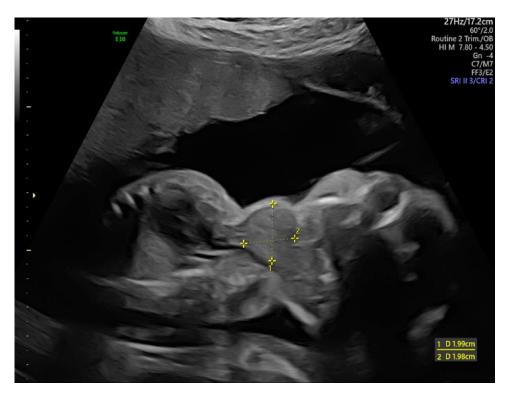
Ultrasound showing fetal neck mass with size indicated by yellow markings.
